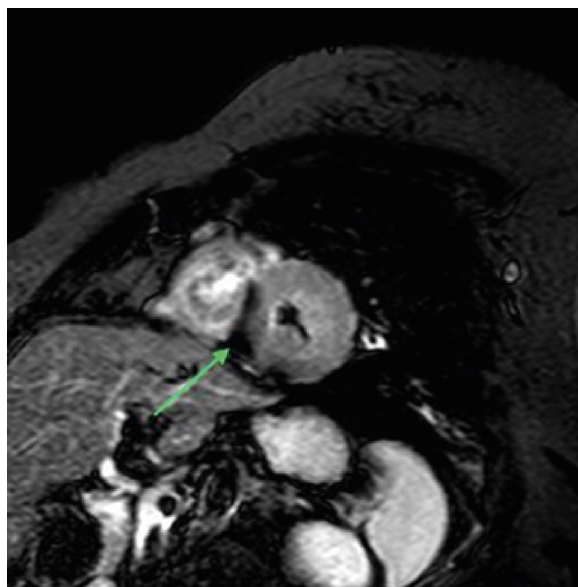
T2-weighted black-blood sequence with fat saturation (short tau inversion recovery) showing focal hyposignaling in the mid-inferoseptal segment (arrow).
